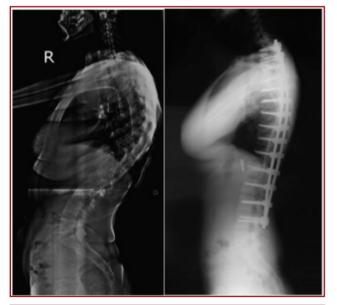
Preoperative and last follow up lateral x-rays showing sagittal plane changes.
